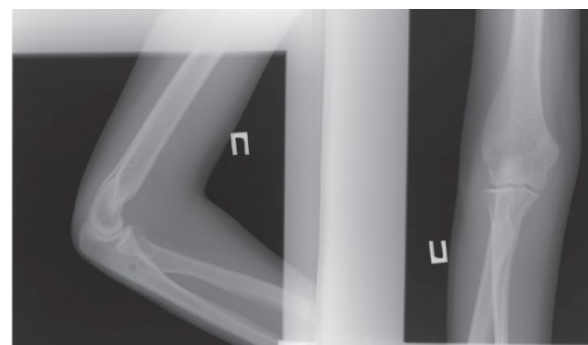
Radiographs of the elbow joint in two projections 12 months after surgery
